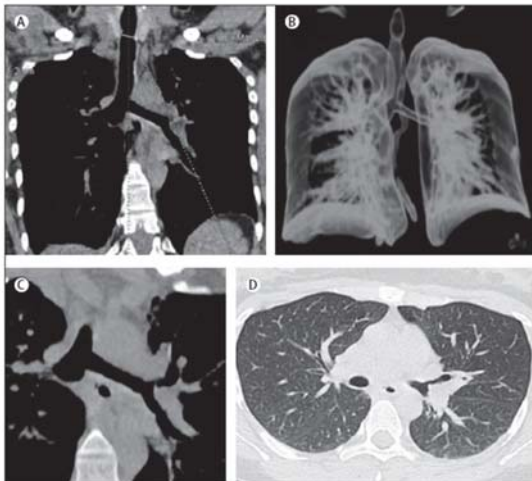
Imaging findings at 5 years after transplantation. Multidetector CT scan (March, 2013) showing the entire graft with a normal proximal anastomosis (A) coronal view; (B) 3D reconstruction. Multidetector CT scan (March, 2013) showing a normal distal anastomosis (C) with a normal inflated lung (D).
